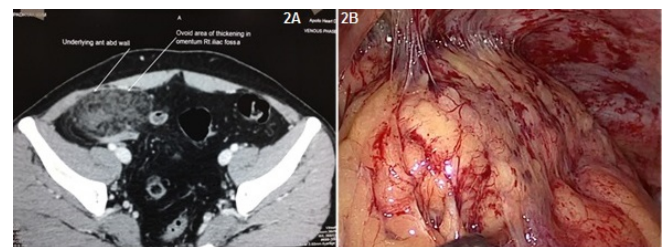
CT scan showing an omental mass adherent to anterior abdominal wall. 2B. Intraoperative image showing omental mass adherent to anterior abdominal wall at the site of previous surgery.
